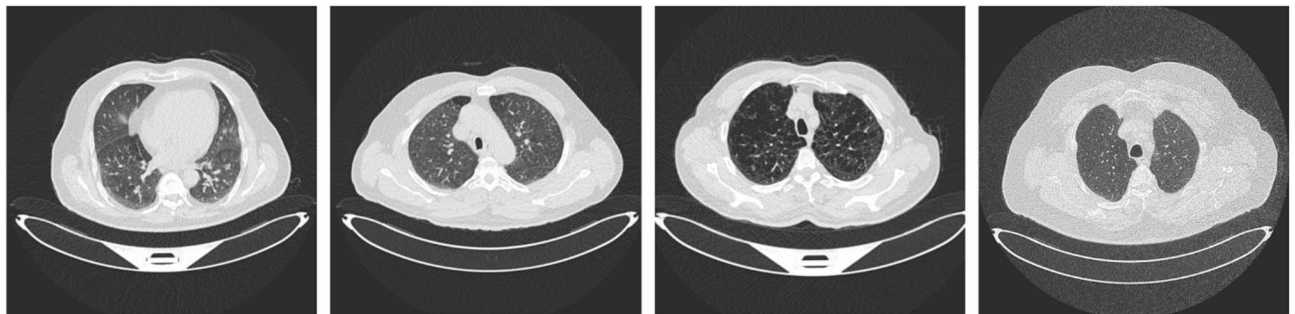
Representative CT scans from the LIDC-IDRI dataset showing annotated lung nodules.
